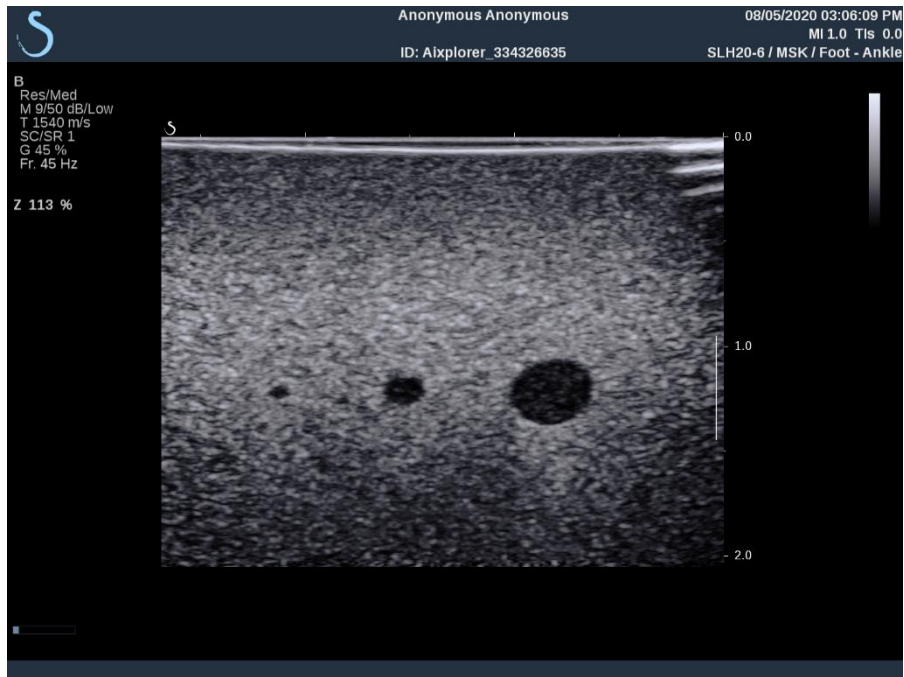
Ultrasound image used for the geometric check. Captured with the stock SLH20-6 probe.
